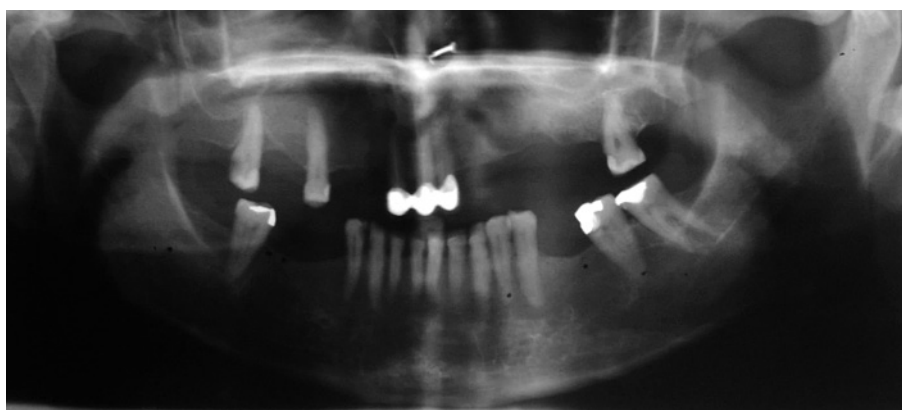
Panoramic radiograph showing generalized moderate interdental bone loss
